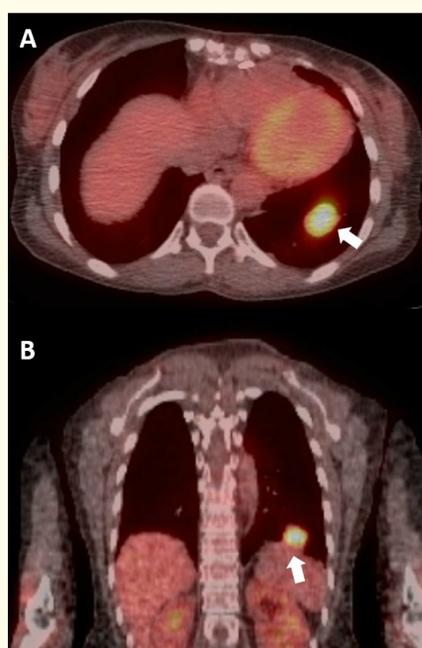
PET CT showing the FDG avid left lower lobe lung mass (SUV = 6.1) (white arrow) in horizontal (A) and vertical (B) cuts without any evidence to suggest metastatic disease.
